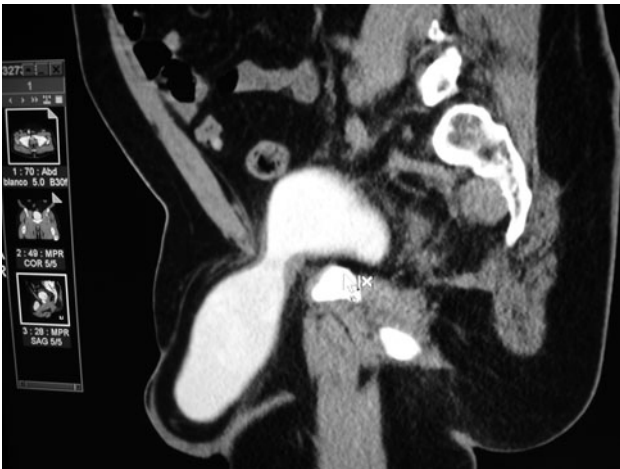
Saggital computed tomography (CT) image with contrast in the bladder demonstrates bladder herniation
